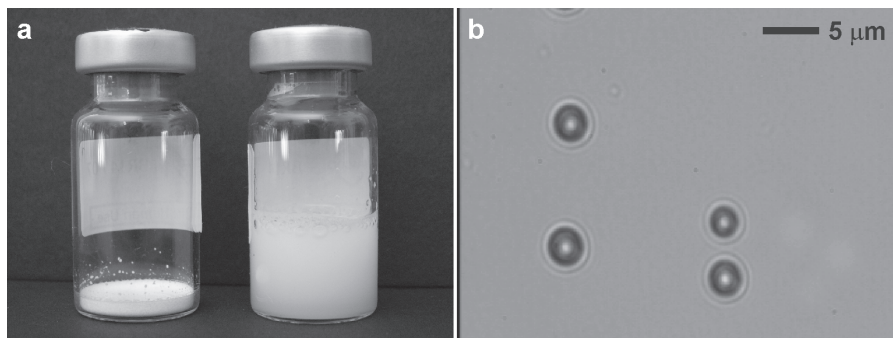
a) Ultrasound contrast agent (UCA) before (left) and after (right) solving in 5 ml sodium chloride solution. After solving, the UCA can be administered. b) UCA consist of microbubbles.
